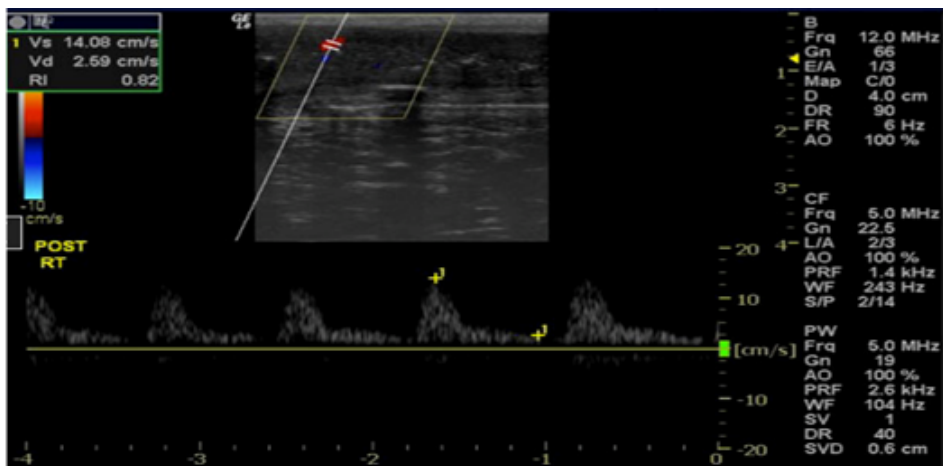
Doppler Ultrasound demonstrating Arterial Insufficiency: Erectile Dysfunction.
